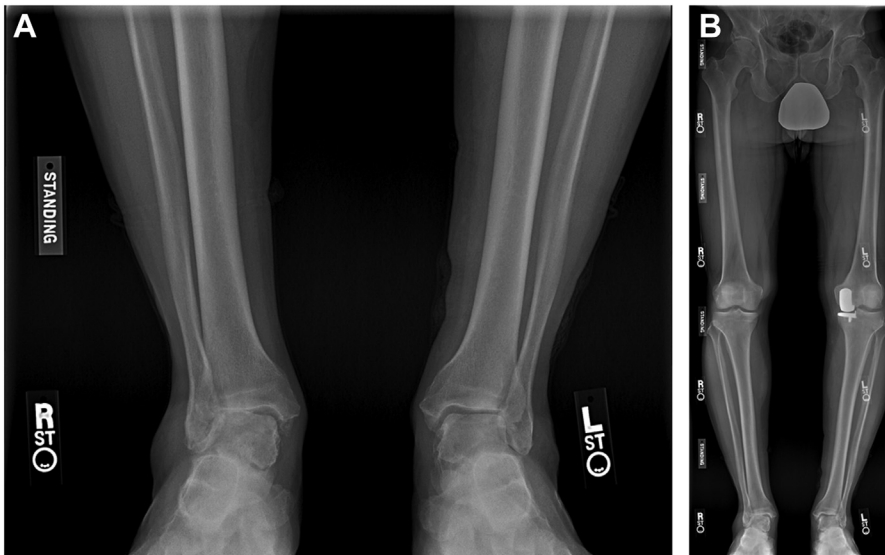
(A) Valgus ankle arthritis seen on anteroposterior (AP) ankle radiograph, with varus knee deformity as potential cause seen on long-leg alignment views (B).
